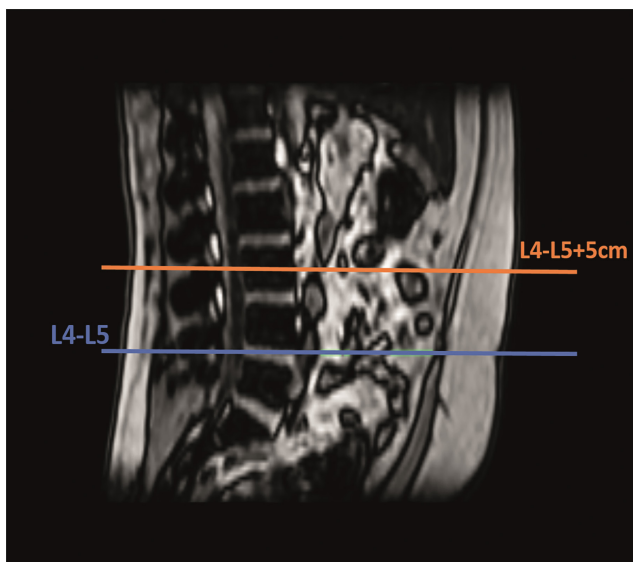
Visualization of the levels used for retrospective evaluation of VAT using MRI scans from original study,<sup>18</sup> midsagittal plane.
